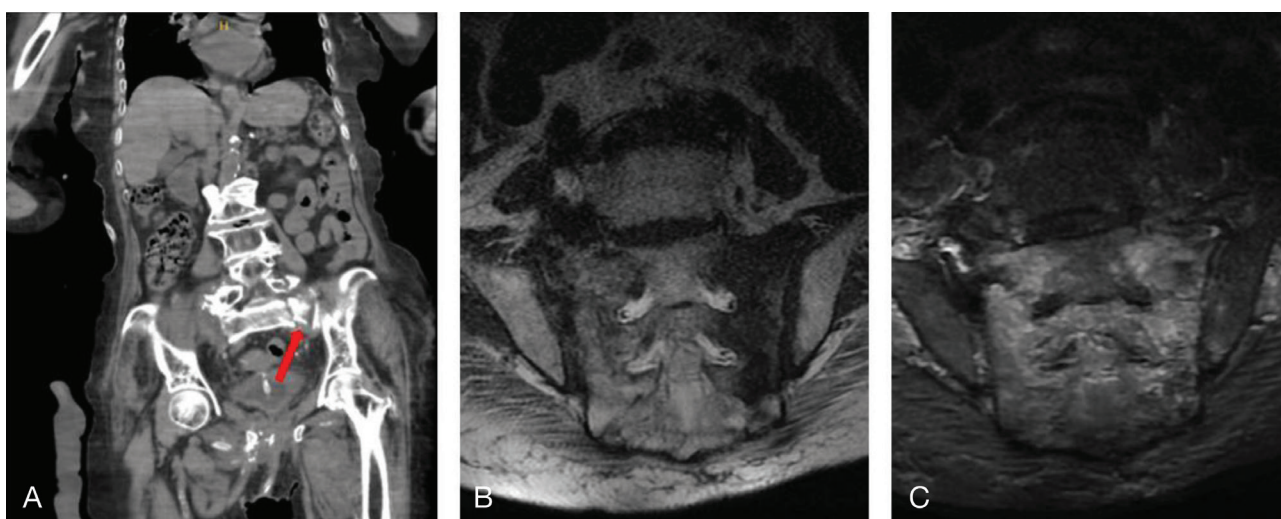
(A) The red arrow indicates a fracture line in the left sacrum in the coronal plane on CT. (B) T1-weighted MRI shows hypointense changes in the sacrum. (C) T2-weighted MRI shows hyperintense changes in the sacrum
